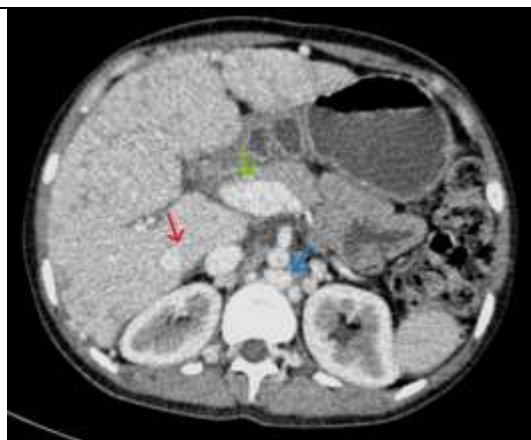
Axial CT section showing inhomogeneous mottled liver, thrombosis of intra-hepatic portion of IVC (Red arrow), dilatation of the portal vein (green arrow), and collateral venous circulation (Blue arrow)
